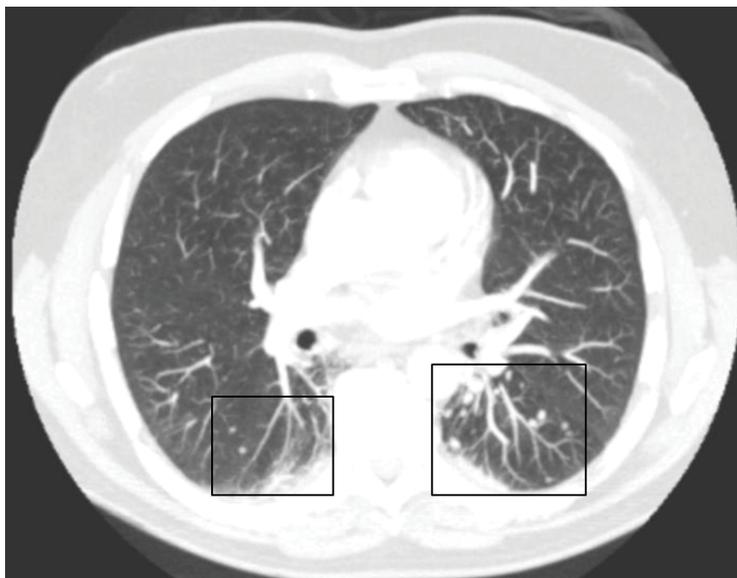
Horizontal CT single slice. Black frames highlight multiple well circumscribed > 0.5 cm Caplan's nodules throughout lower lobes bilaterally, more marked on left than right.
